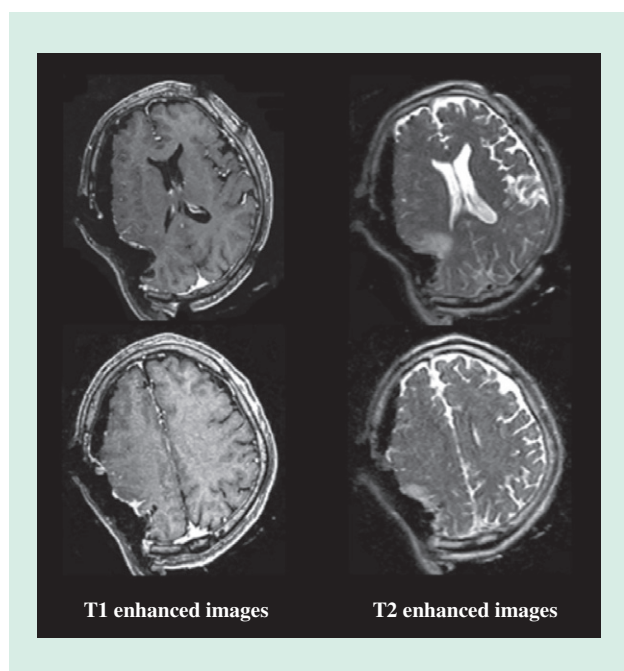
Images Captured by Intraoperative MRI Imaging (Source: Kagoshima University Medical and Dental Hospital). The photograph shows two sets of cross-section cranial images with different contrast. Image data is captured in three dimensions and sent to the surgery navigation system.
